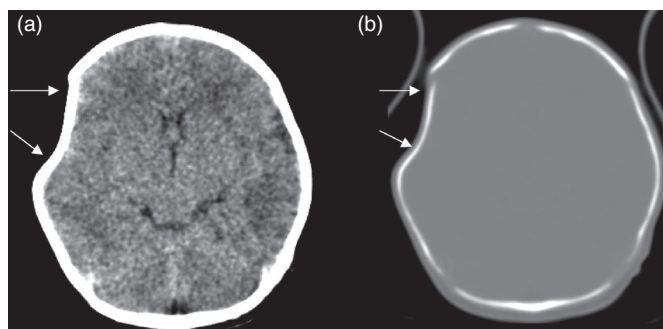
Right frontal cranial depression (arrows) on CT with (a) soft tissue and (b) bone algorithms.
